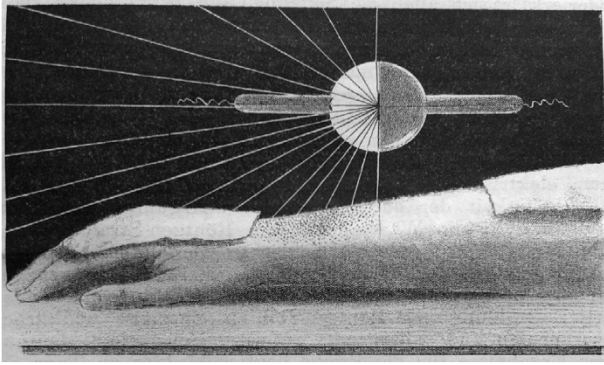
Crucial experiment performed 1900, proving X-ray dose as the biologically effective agent. Fig. 6 from [24].
